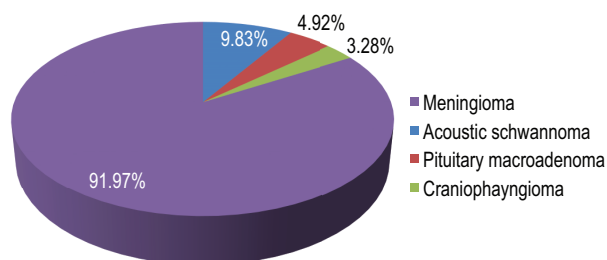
Showing percentages of Intra cranial extra axial tumors distribution by our MRI study.
